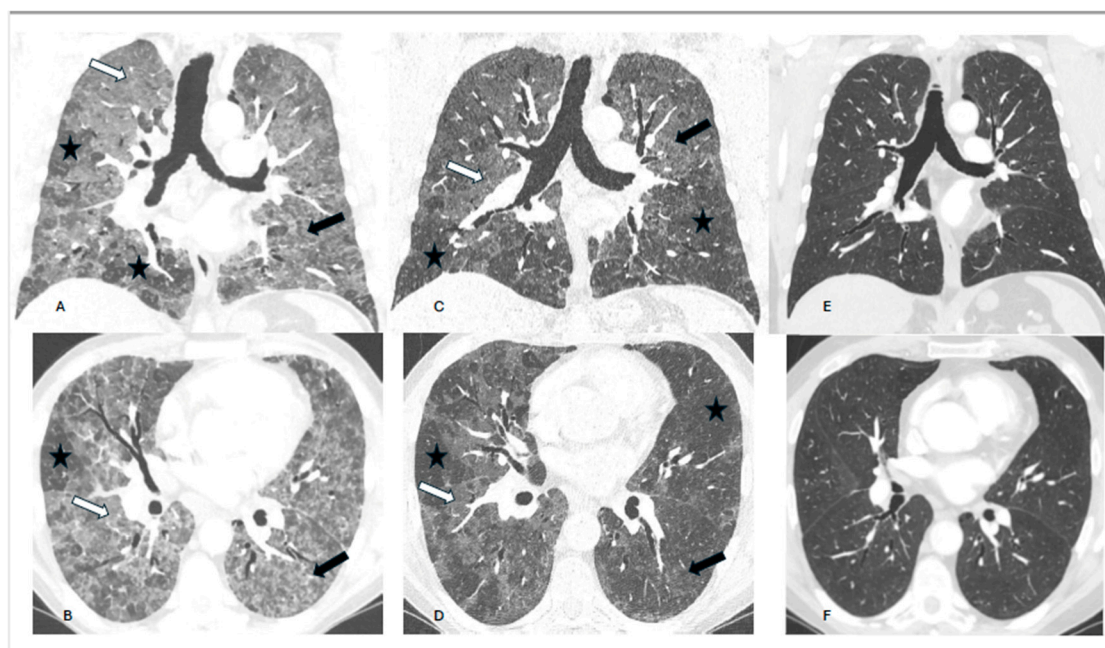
Patient 2 - HRCT scans coronal and axial planes. A, B – baseline scans, C, D – follow-up after three months, E, F – follow-up after a year. A, B: Lobular areas with poorly defined small centrilobular nodules (black arrows), ground glass opacities (white arrows) and with lobules of normal appearance suggestive of air trapping (asterisks). C, D: Partial regression of the interstitial lesions; E, F: Further (nearly complete) regression of lung opacities.
